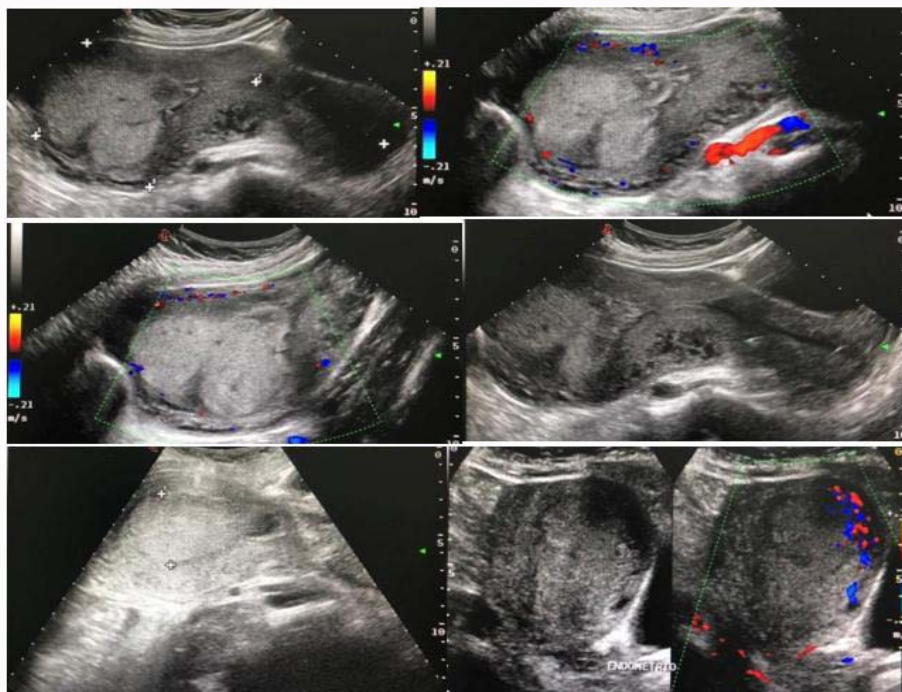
VA uterus measuring 135 mm × 57 mm × 76 mm, with regular borders, homogeneous myometrium without evidence of lesions. Central endometrium, maintains interface with the myometrium, thickening of up to 27 mm, it is observed heterogeneous, and predominantly hypoechoic with an anechoic area inside that, after the application of color Doppler at the level of the uterine fundus, vascularity is identified at the level of the endometrial myometrial junction.
